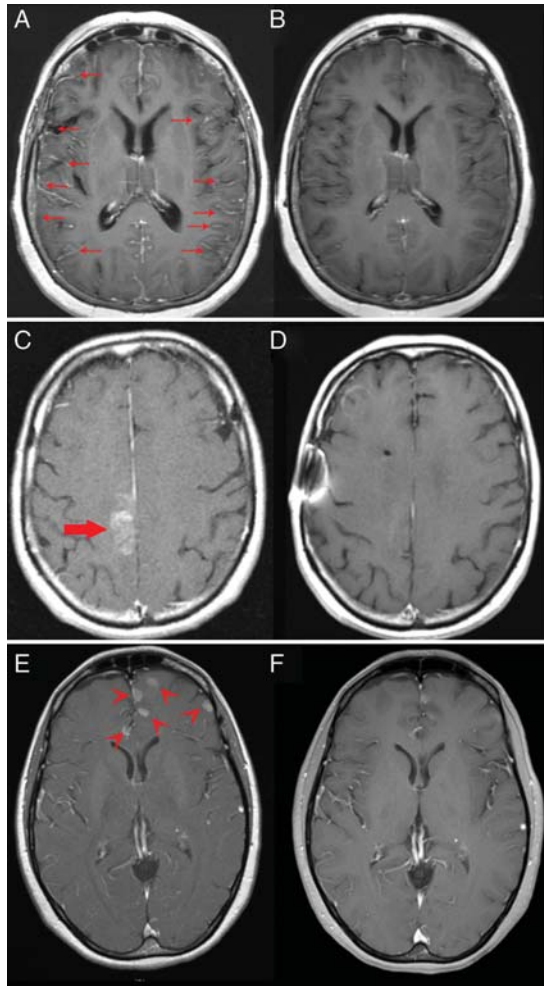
Response of CNS metastases to pulsatile erlotinib in 3 patients. Contrast (gadolinium)-enhanced axial T1 MRI sequences in patient #3 with leptomeningeal metastases (arrows) before (A) and after (B) 6 months of therapy. Patient #6 with coexistent brain (large arrow) and leptomeningeal metastases (not shown) before (C) and after (D) 5 months of therapy. Patient #8 with coexistent brain (arrow heads) and leptomeningeal metastases (not shown) before (E) and after (F) 2 months of therapy.
